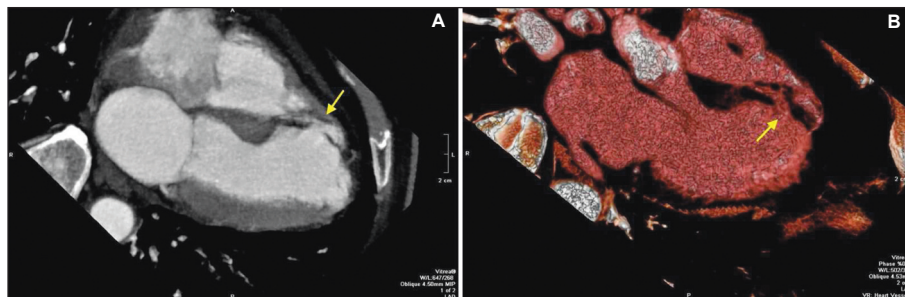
A-B) Cardiac computed tomography angiography showed apical muscular ventricular septal rupture.
